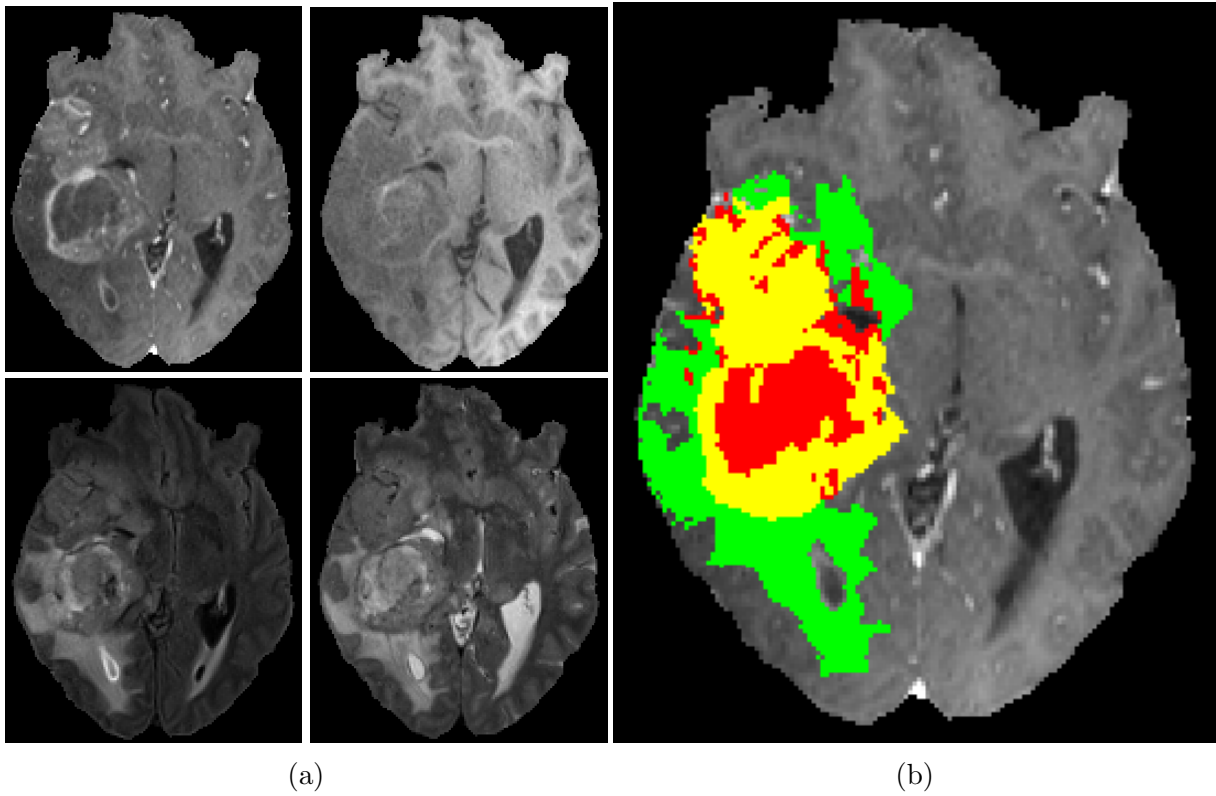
Examples of BraTS multimodal scans and Glioma sub-regions. (a) MRI Slices: T1-weighted (top left), native T1 (top right), FLAIR (bottom left), T2 (bottom right), (b) Segmented regions: edema (green), necrotic (NCR) and the non-enhancing (NET) tumor core (red), enhancing tumor (yellow)
